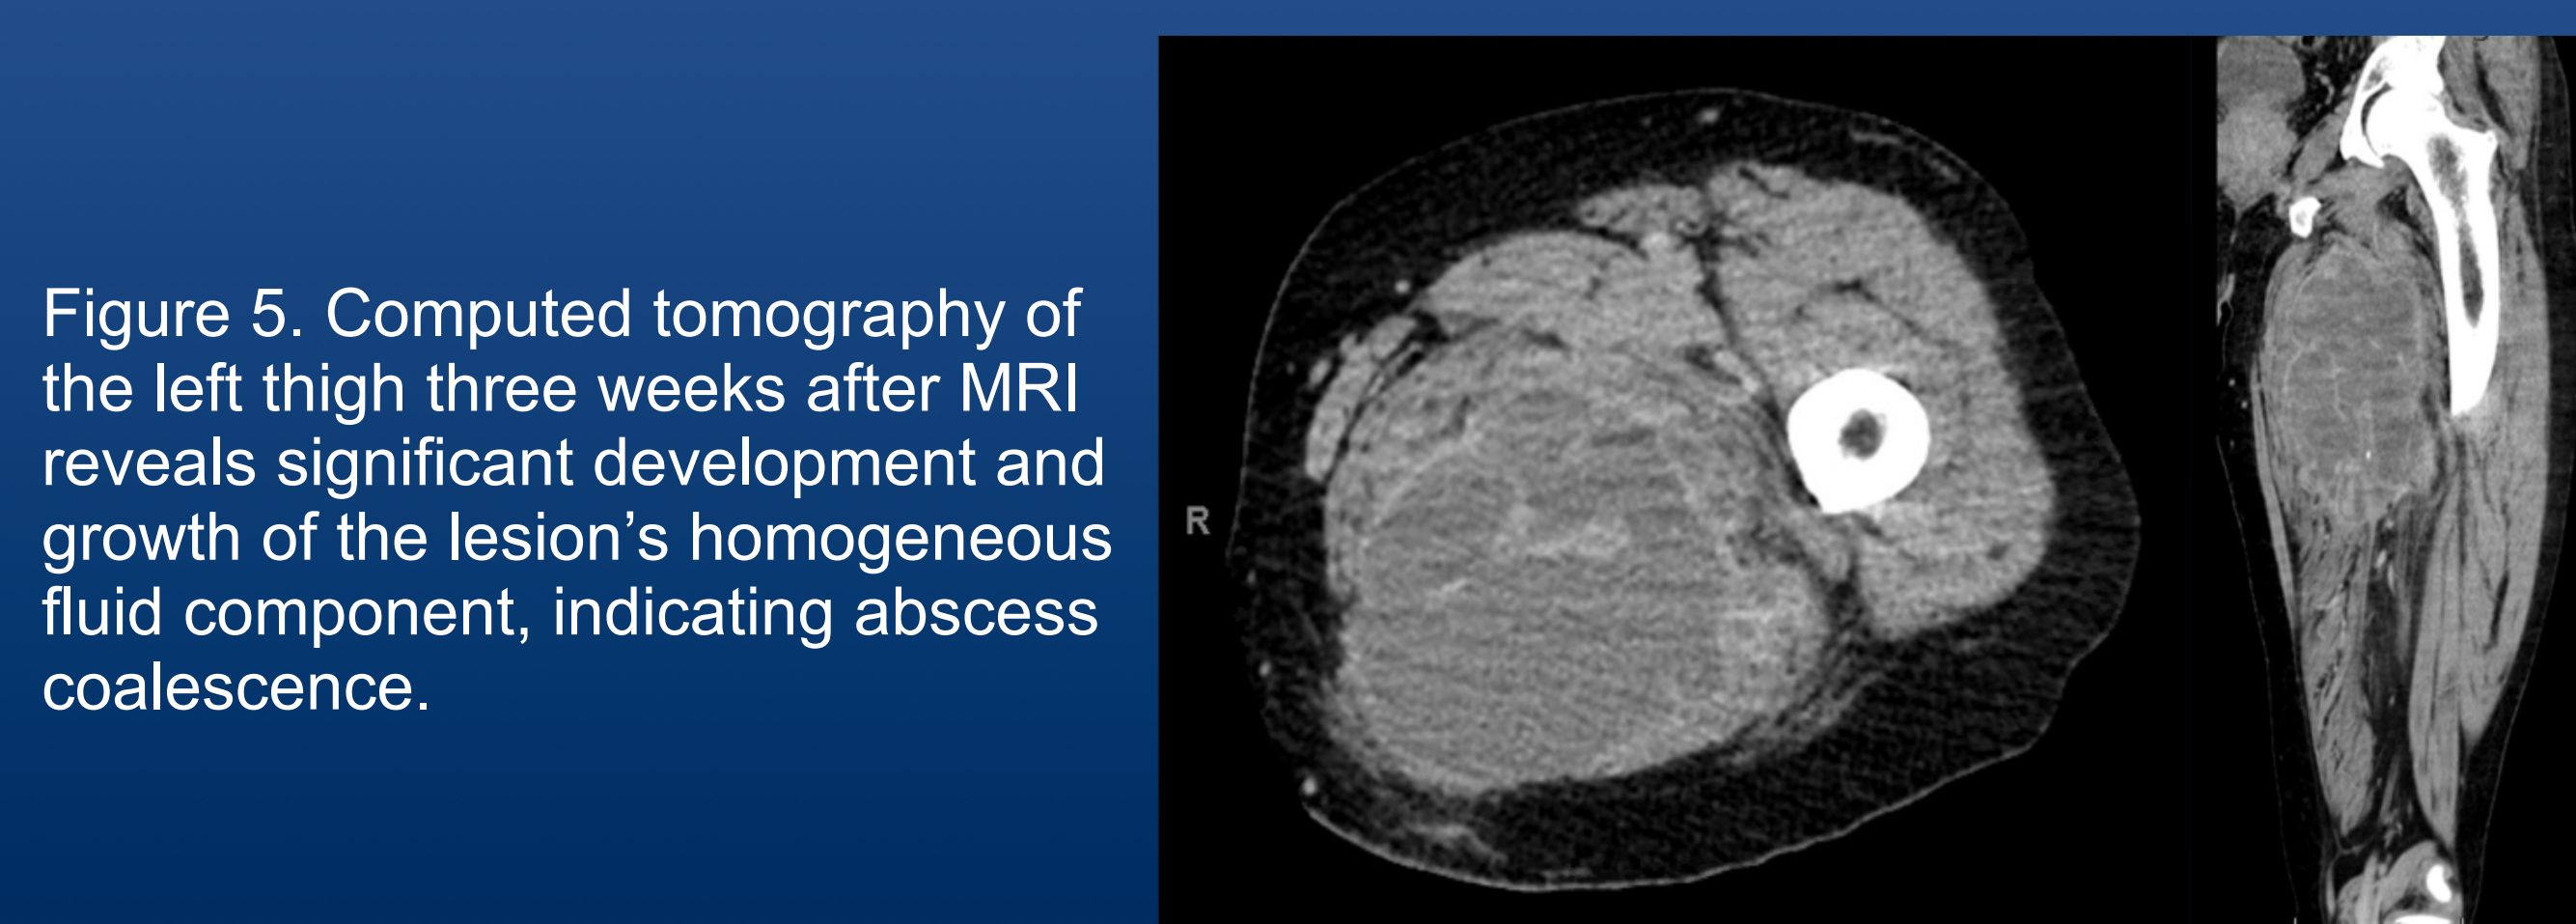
Computed tomography of the left thigh three weeks after MRI reveals significant development and growth of the lesion's homogeneous fluid component, indicating abscess coalescence.
